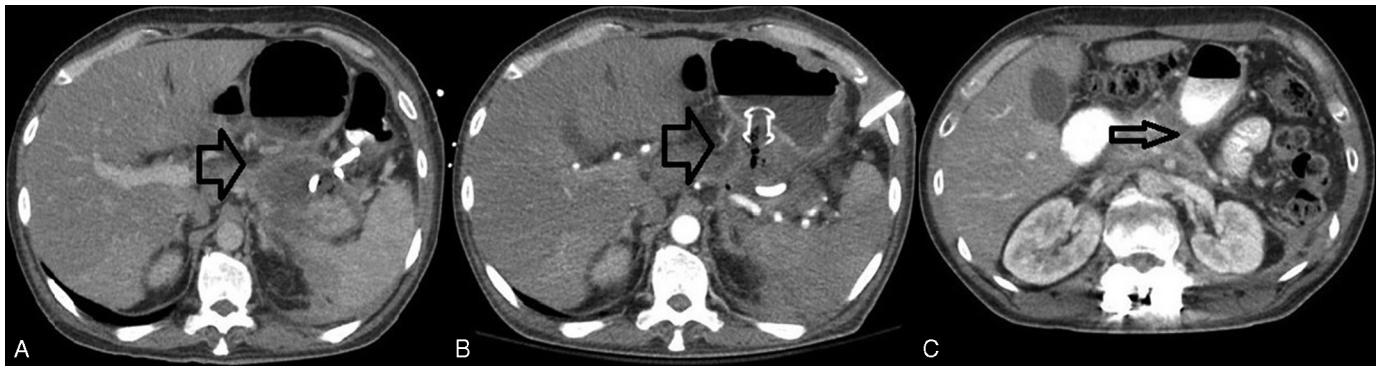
(A) CT of the abdomen and pelvis showing a persistent 11 x 8 cm walled-off necrosis (WON) with percutaneous drain in proper position. (B) CT of the abdomen and pelvis after 5 weeks (prior to upsizing of percutaneous drain) showing persistent WON with AXIOS stent and percutaneous drain in proper positions. (C) A follow-up CT scan 6 weeks after the last direct endoscopic necrosectomy showing no recurrence of the WON.
